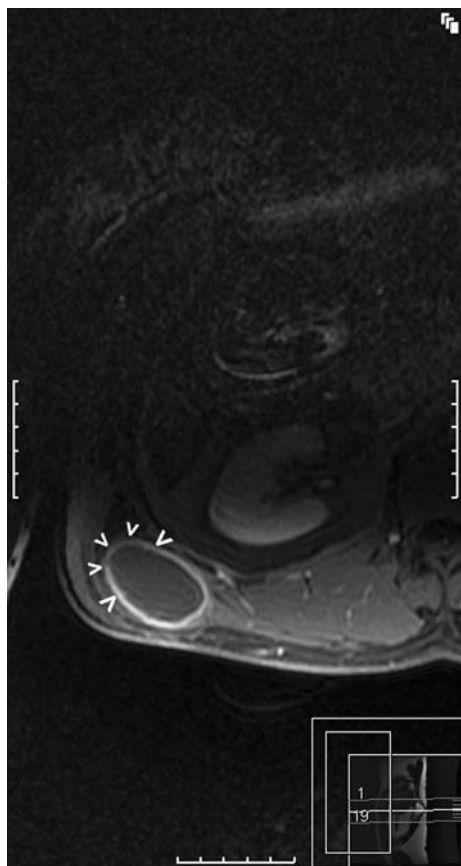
C On (A) sagittal and (B) axial T2-weighted turbo spin-echo images and (C) a coronal STIR sequence, a small dot (>) can be seen, which is consistent with a scolex.
